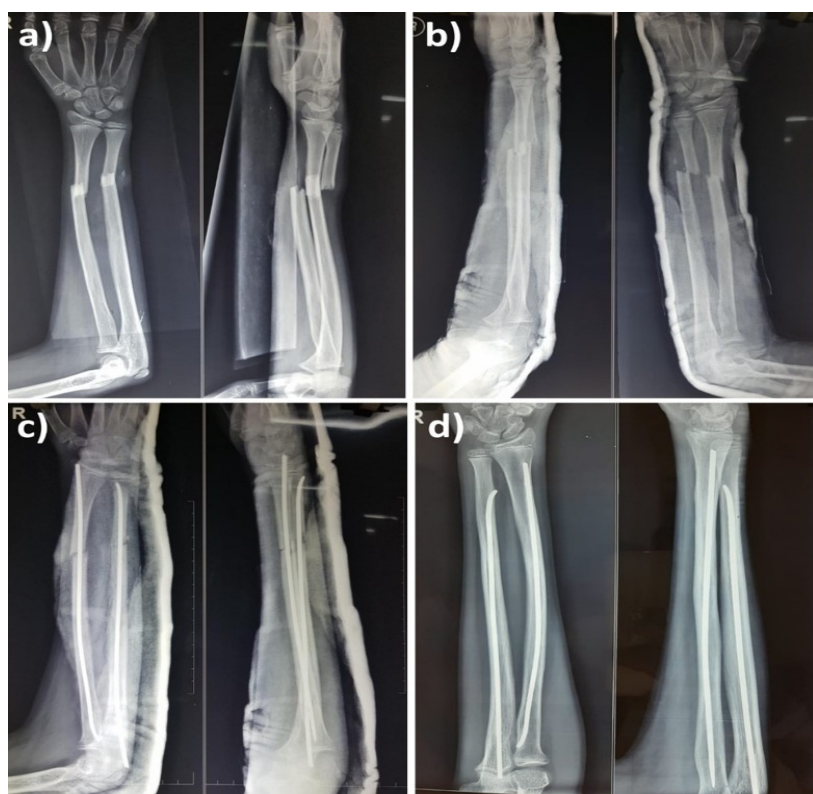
Anteroposterior and lateral radiographs of the right forearm of a 14-year-old boy (a) at presentation. (b) After closed reduction (reduction was attempted considering his age), (c) following titanium elastic nailing, and (d) at 7-month follow-up showing good alignment and fracture union with maintenance of radial bow.
